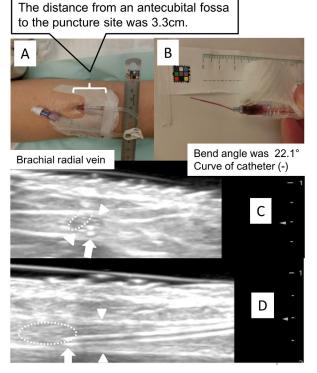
Upper arm vein (CF): Case 22302. (A) Upper arm insertion site. (B) Bend angle. (C) Ultrasound image before catheter removal (transverse image). (D) Ultrasound image (longitudinal image). Ultrasound images showing vessel wall (arrowheads), catheter tip (arrows), and thrombus (dotted circle).
